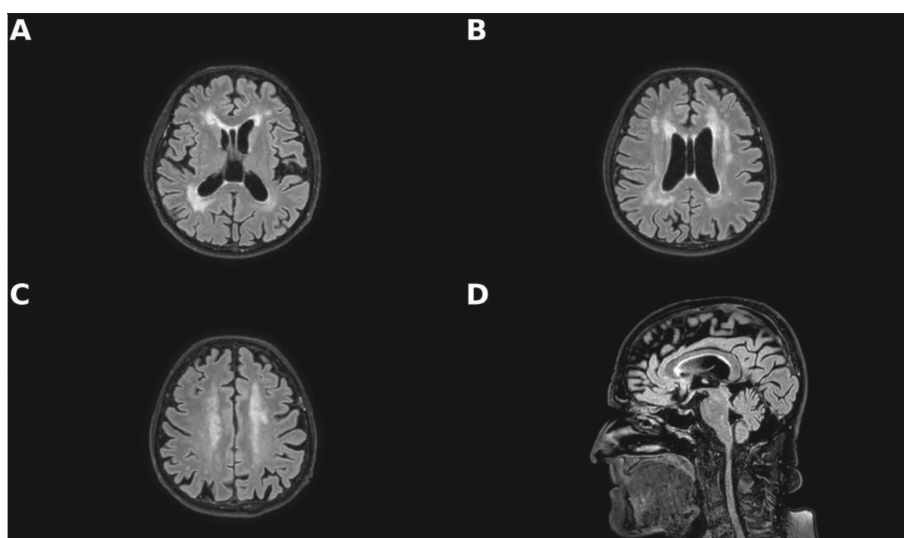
Brain magnetic resonance imaging of the case. (A–C) FLAIR sequences reveal high signal changes in the periventricular white matter and mild brain atrophy. (D) The corpus callosum appears to be of normal thickness on the sagittal FLAIR sequence.
